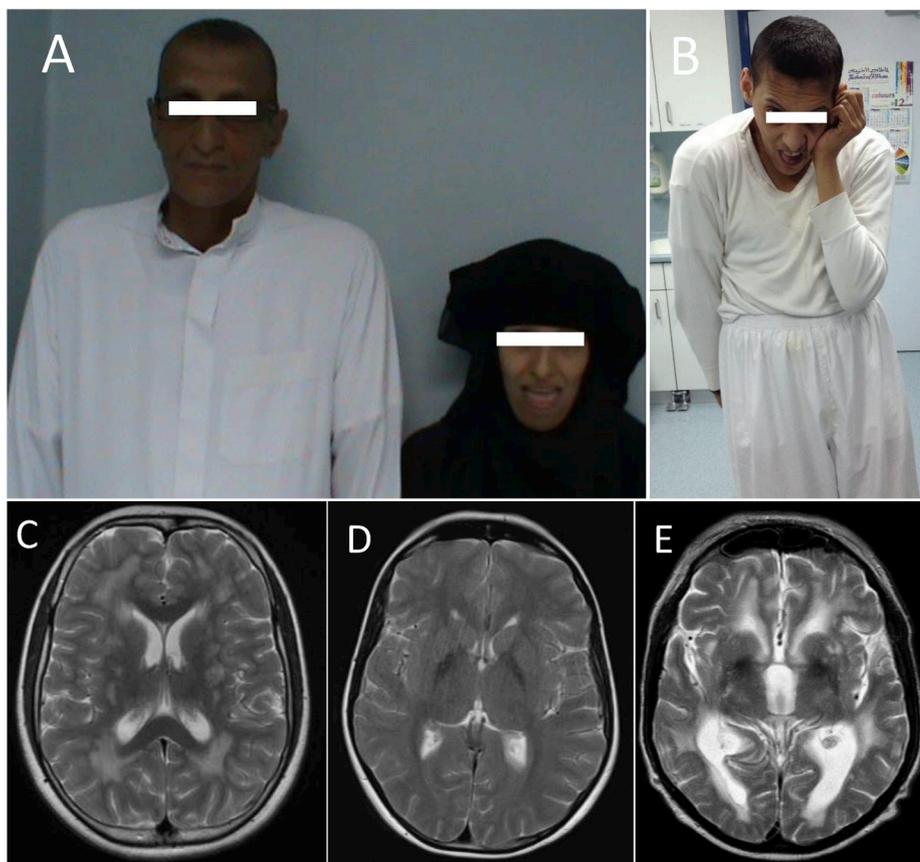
Extrapyrarnidal involvement. Clinical photographs of patients with WSS and their brain MRIs. Figure (A) shows two siblings with type 2 WSS. The male patient has temporal alopecia and a triangular face with no dystonia. His affected younger sister (a, right) shows oromandibular dystonia. Truncal, oromandibular and upper limb dystonia seen in a patient with type 1 WSS (B). Figures C and E show prominent periventricular white matter lesions on axial brain MRI T2-weighted images.
